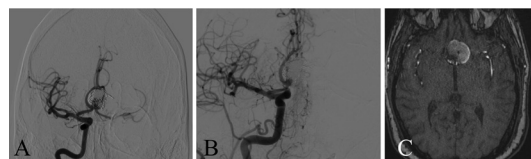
Cerebral angiogram anterior–posterior view (A) and lateral view (B) and T1 postcontrast MRI (C) demonstrating residual filling of ACoA prior to endovascular reintervention. ACoA, anterior communicating artery aneurysm.
